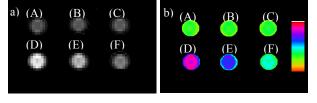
(a) *In vitro* MR images of HEK293 cells for 4 h at 37.0 ± 0.1 °C. A) Control (cell only); (B) Cells treated with 1.0 mM Gd(III) complex; (C) Cells treated with 1.0 mM Cu(II); (D) Cells treated with 2 mM Cu(II) and 2 mM [Gd(Try-TTDA)]²⁻; (E) Cells treated with 1 mM Cu(II) and 1 mM [Gd(Try-TTDA)]²⁻; (F) Cells treated with 0.5 mM Cu(II) and 0.5 mM [Gd(Try-TTDA)]²⁻.
